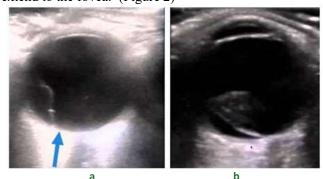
Ultra-sonographic images of a) Mac- On and b) Mac- Off Retinal Detachments
